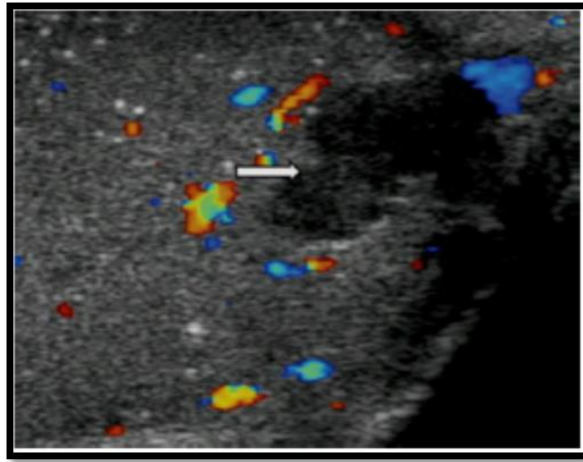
shows the Intra testicular hematoma. A well-circumscribed (arrow) focal area of low reflectivity with internal echoes is noted in the testis of a patient involved in a motorcycle accident. The lesion demonstrates low reflectivity. Color Doppler ultrasound confirms absence of vascularity, in keeping with the diagnosis of traumatic intra testicular hematoma. At 4 weeks there was reduction in size of the lesion. Incidental microlithiasis is present (Purushothaman et al, 2007).
